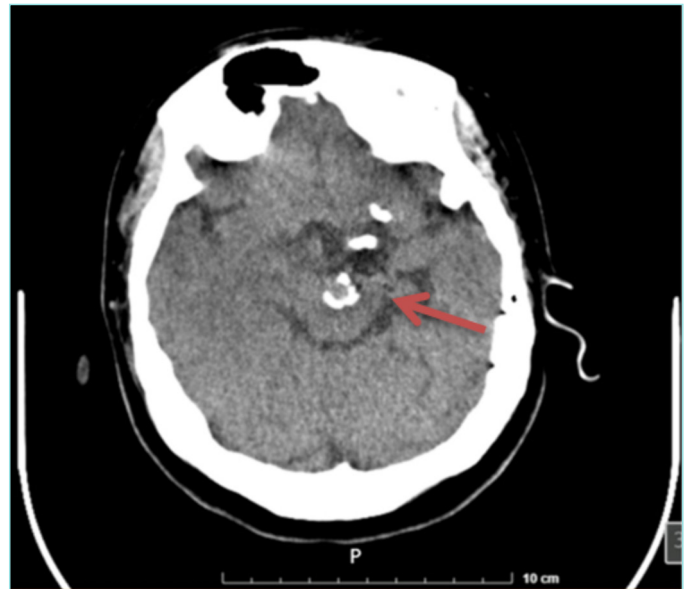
Brain computed tomography angiography demonstrating a prefrontal and suprasellar arteriovenous malformation characterized by dilated serpiginous vascular structures arising from the basilar artery (red arrow), with associated calcifications and a nidus measuring 27×25 mm.
